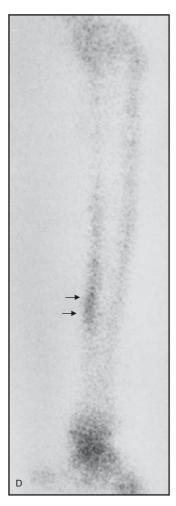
Bone scintigraphy. Arrows show abnormal longitudinal uptake in lateral view (reproduced from Aoki et al., $^{\left[27\right]}$ with permission).
